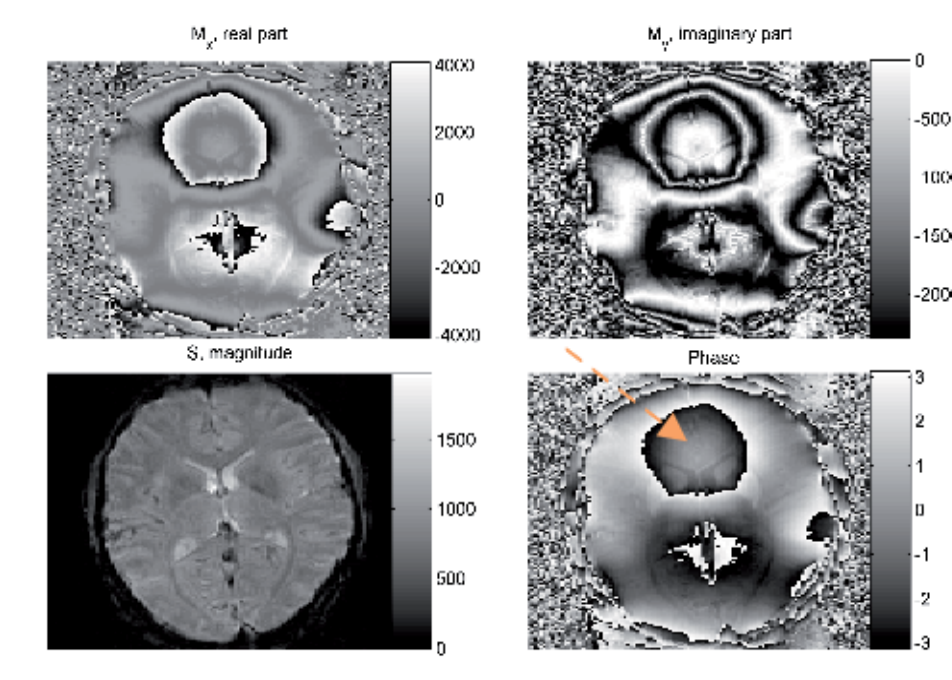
The MRI detection system subdivides the image information into a real and an imaginary component, corresponding to the M_x and the M_y components of the transverse magnetization. These components define a complex vector and can be rearranged to form the length [Eq. 6] and the argument [Eq.7] of the vector, corresponding to the MRI magnitude and phase signals, respectively. The red arrow indicates the area just above the frontal sinuses with strong magnetic field variations, due to the difference in susceptibility between the air in the frontal sinuses and the brain tissue.
